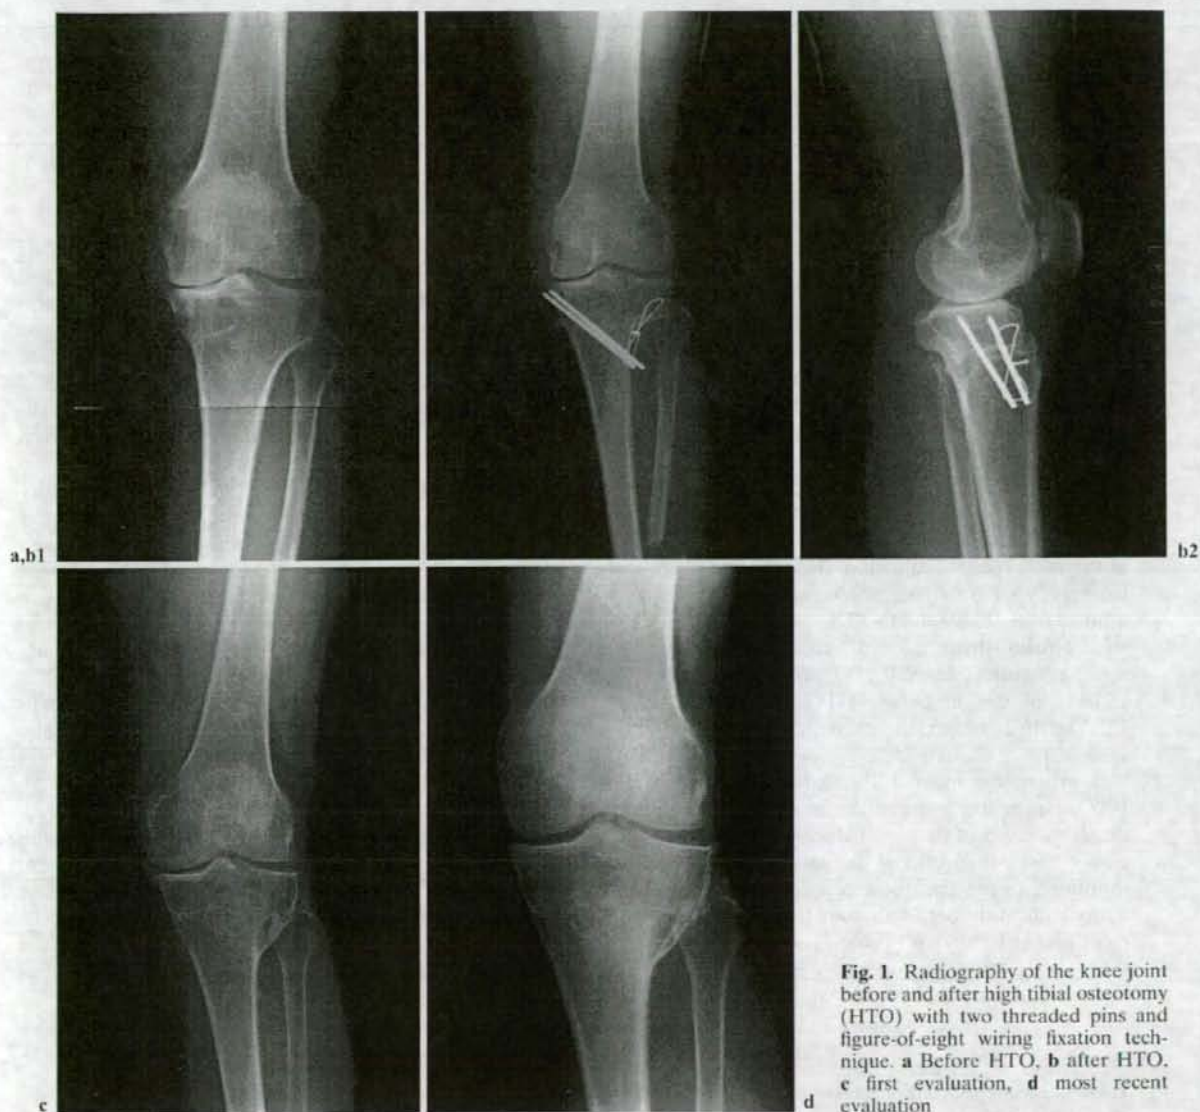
Radiography of the knee joint before and after high tibial osteotomy (HTO) with two threaded pins and figure-of-eight wiring fixation technique. a Before HTO, b after HTO. c first evaluation, d most recent evaluation
